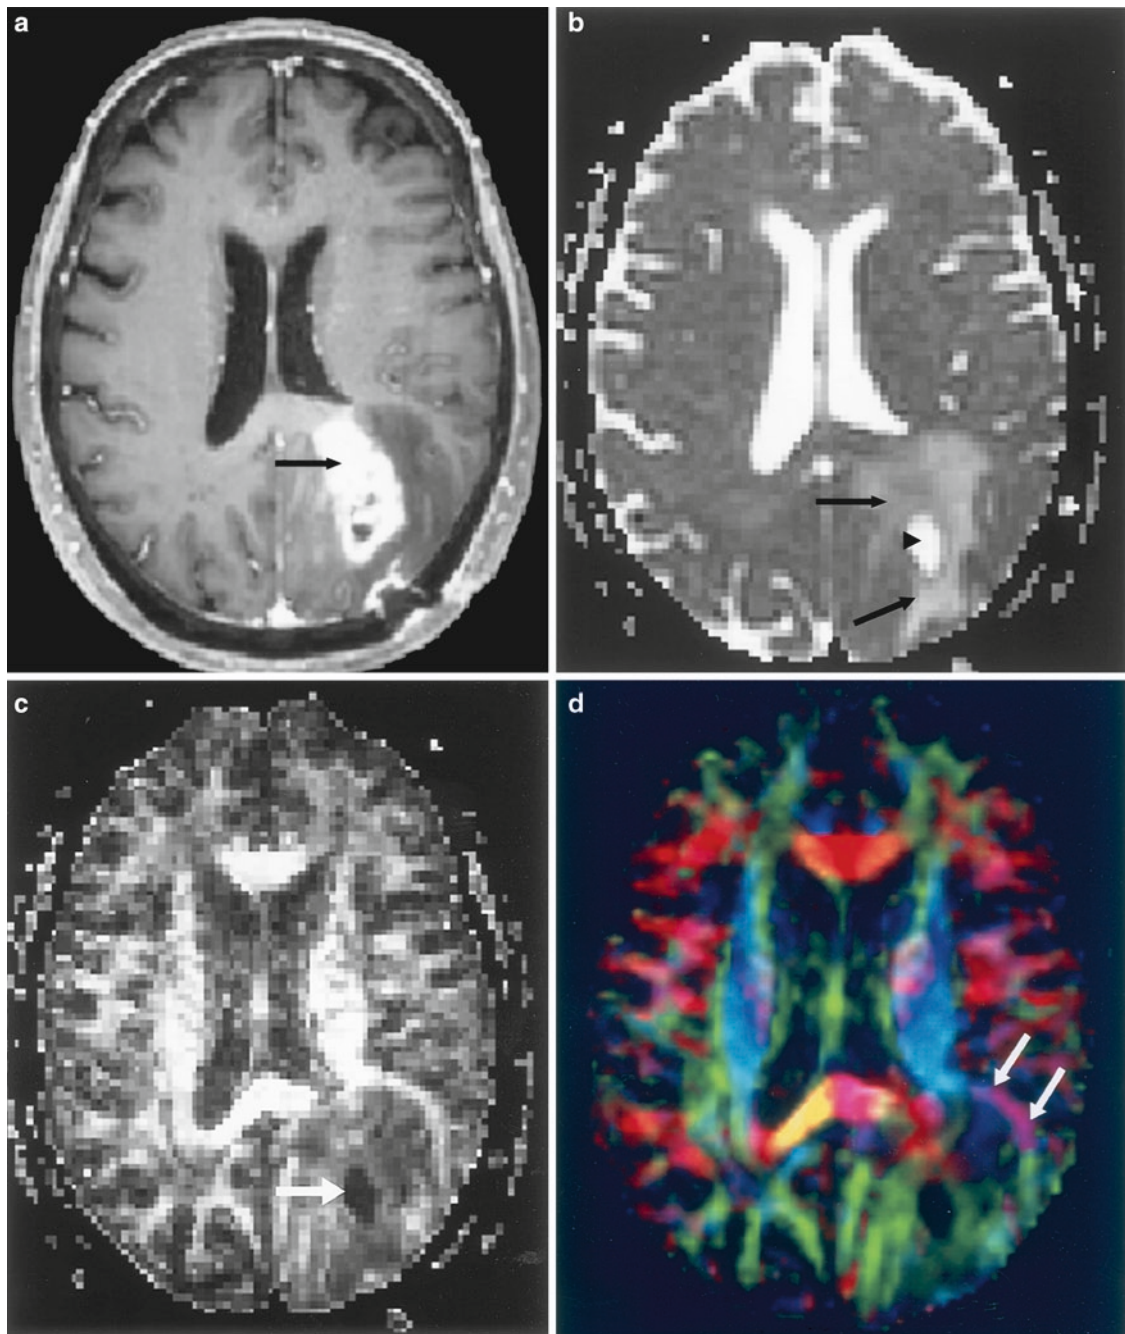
(a–d) MRI performed prior to treatment in a 62 year old female with biopsy proven glioblastoma in the left occipital lobe. (a) Postcontrast-enhanced axial T1-weighted images demonstrate a large heterogenous contrast enhancing mass in left occipital lobe with involvement of the splenium of the corpus callosum and effacement of the left atria (*black arrow*); (b) increased signal due to increase diffusivity is demonstrated on the ADC-maps (*black arrows*) with a focal area of even brighter signal representing a small area of necrosis within the tumor (*black arrowhead*); (c) a reduction of the fraction anisotropy can be seen as focal regions of decreased signal (*dark*) on the fraction anisotropy maps (FA-maps) (*black arrow*). (d) The adjacent white matter tracts are destroyed by the tumor as well as the appearance of displaced tracts in the anterior aspect of the tumor can be seen on the directional color encoded image (*small black arrows*) (\*Red = fibers in the *right to left* fiber direction, *green* = fibers running in the anterior posterior direction, and *blue* represents fibers running in the superior inferior direction)
